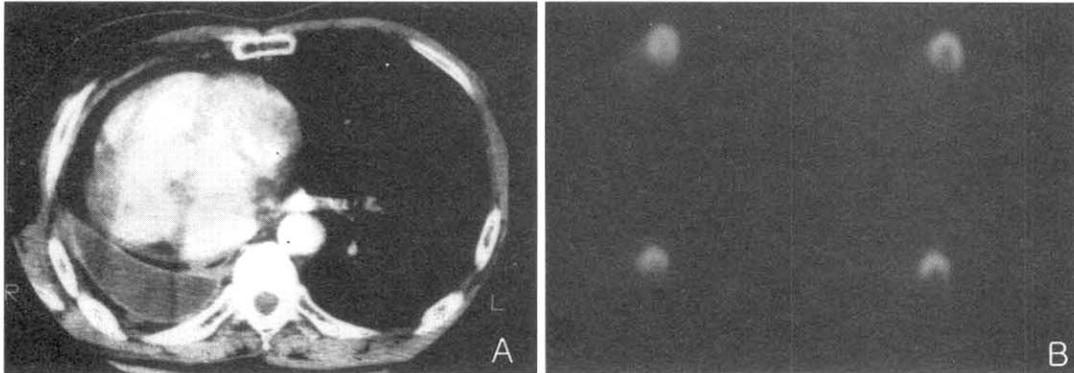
57-year old male patient who had received right pneumonectomy 2 year ago for known squamous cell carcinoma. Postoperative chest CT scan revealed small amount pleural effusion without evidence of chest wall mass or abnormal focal thickening or enhancement of pleura or chest wall (A). 4-hour delayed SPECT images showed no abnormal increased Tl-201 uptakes on chest wall (B).
